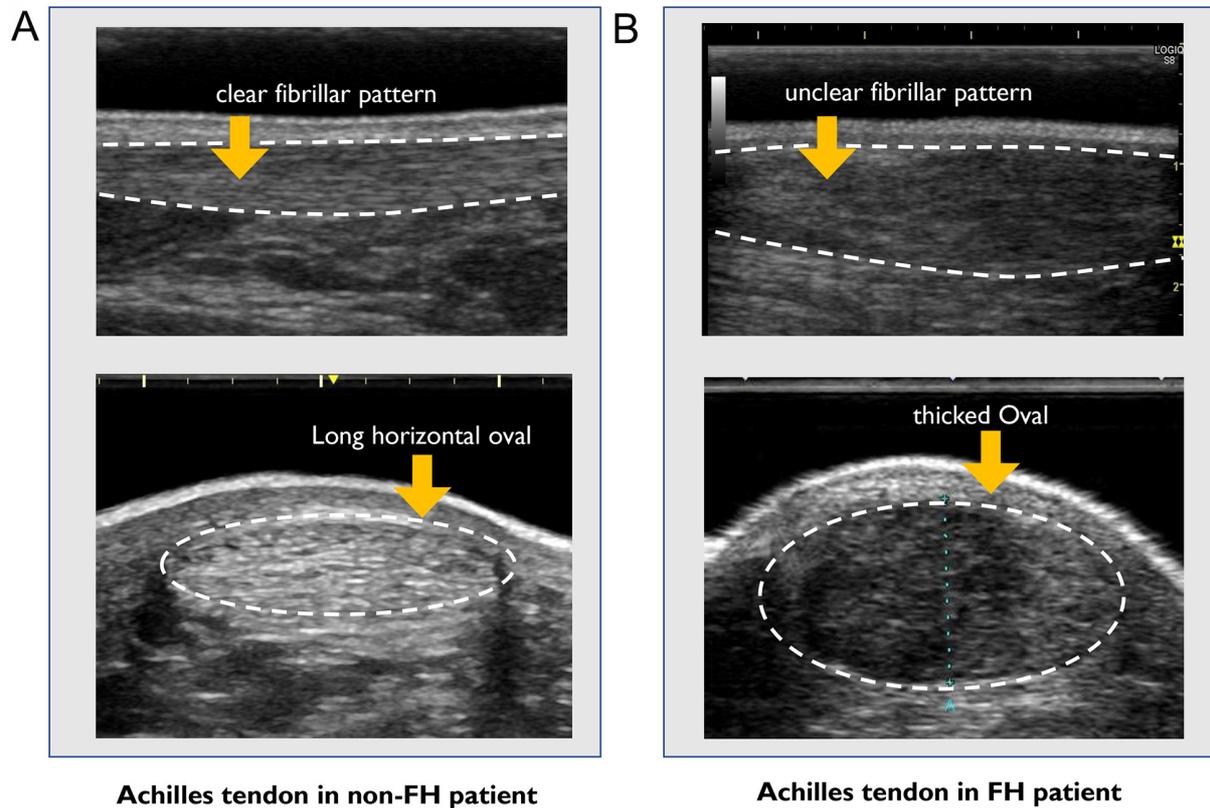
Horizontal and sagittal sonographic appearance of Achilles tendon. (A) sonographic appearance of the Achilles tendon for a 48-year-old male non-FH patient; (B) sonographic appearance of the Achilles tendon for a 24-year-old male FH patient.
